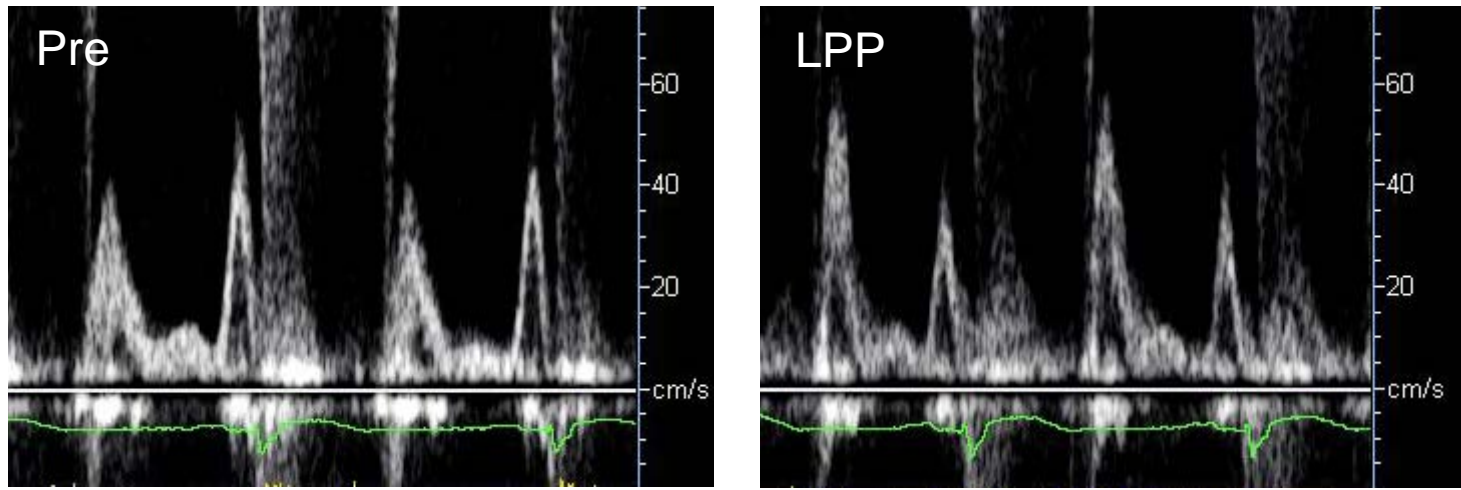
Representative Recordings of Doppler and B-mode Echocardiography at Baseline and during Leg Positive Pressure (LPP).
